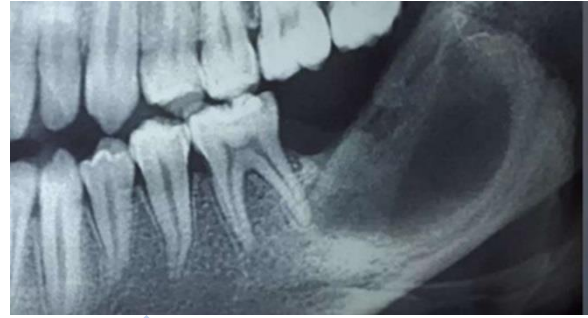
Preoperative radiographic examination
